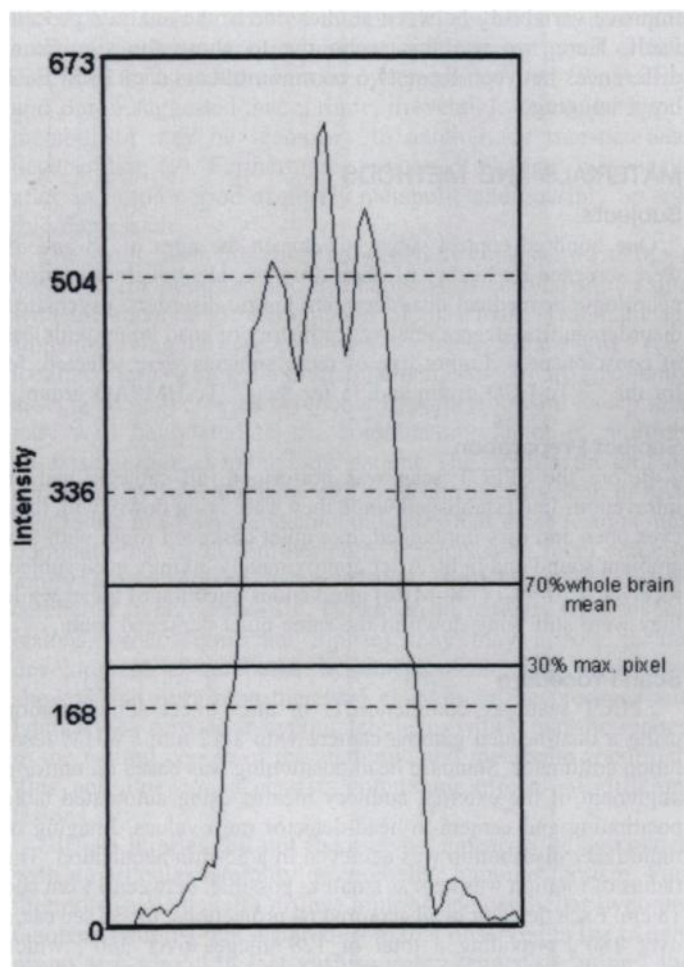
Line profile through a transverse slice of a SPECT image. This graph demonstrates the relationship of the 30% maximum pixel and the 70% whole-brain mean values with an image cross-section. The maximum pixel value varies slightly from image to image and is used as a first approximation to establish a whole-brain mean.
